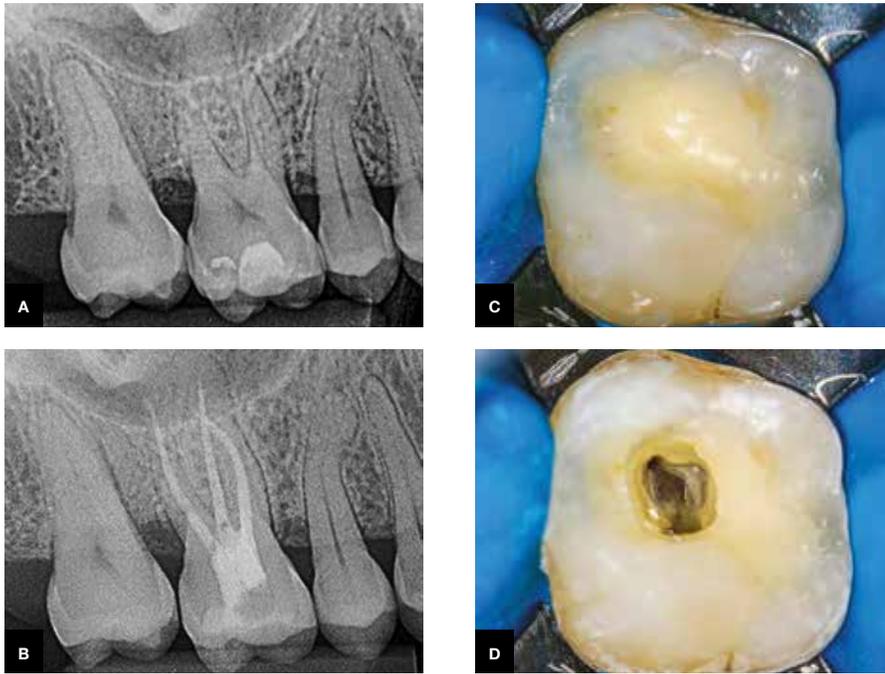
A) Initial radiograph. B) Final radiograph of endodontic treatment. C) Image of the occlusal surface of the tooth before access. D) Post-access occlusal surface.
